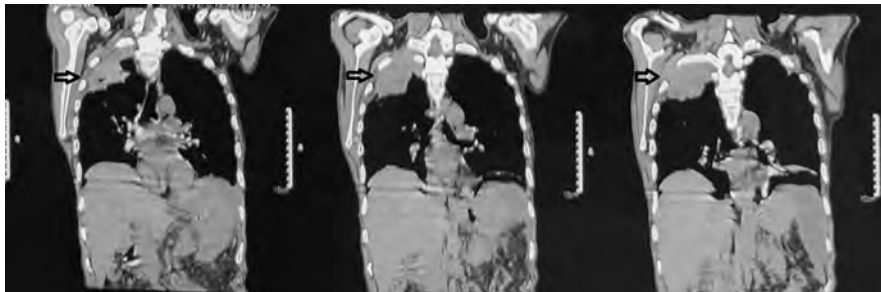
The HRCT thorax shows a malignant mass lesion involving the apical segment of the right upper lobe causing chest wall invasion
